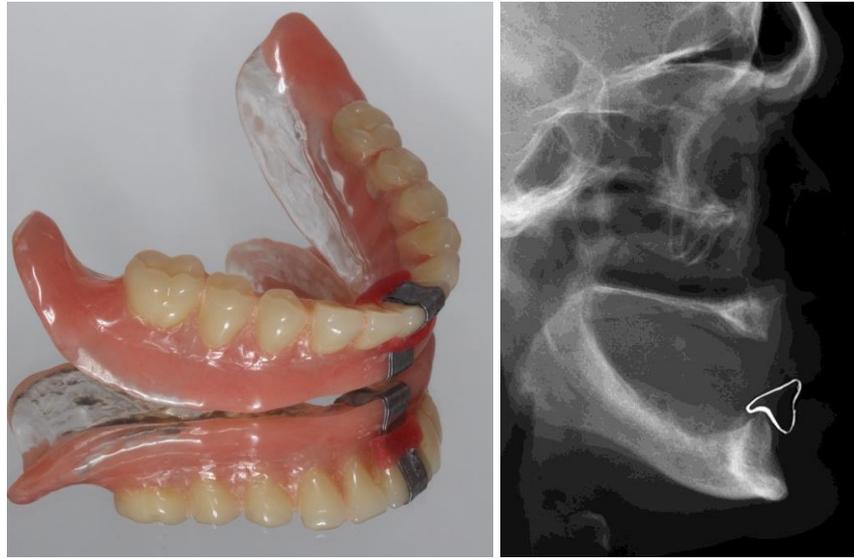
Lead film embracing the mandibular denture prior to image acquisition (left), and lateral cephalometric radiograph.
